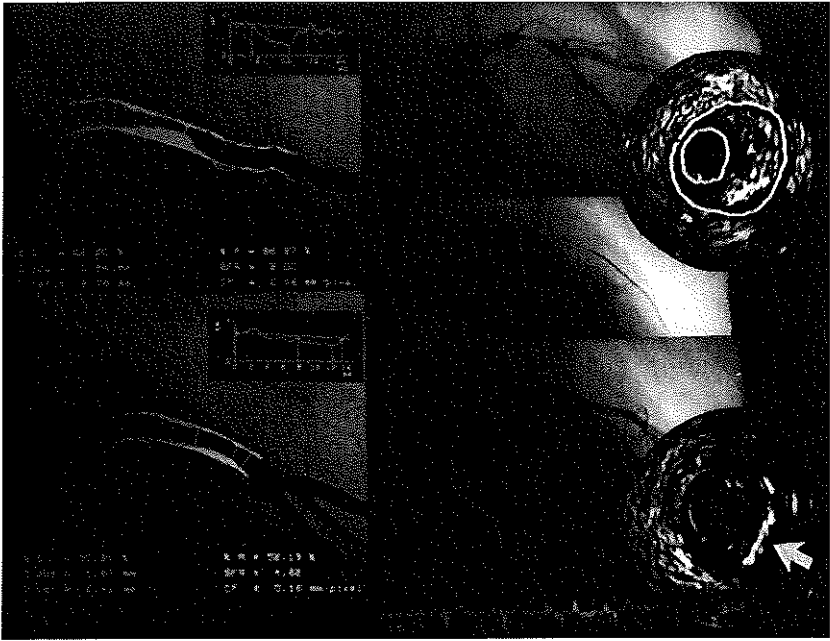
Left panels. Quantitative angiographic assessment of an eccentric left anterior descending coronary artery stenosis prior (upper panel), and post (lower panel), successful rotablator therapy. Right panels. Angiograms prior (upper), during (middle) and post (lower) rotablator therapy with ultrasound images prior (upper) and after therapy (lower). Note the eccentric nature of the, mainly fibrous plaque, with deep seated calcification resulting in some acoustic shadowing, at the 5 o'clock position. Following rotablator therapy most of the plaque has been removed apart from the, previously, deep seated, calcification (arrow).
